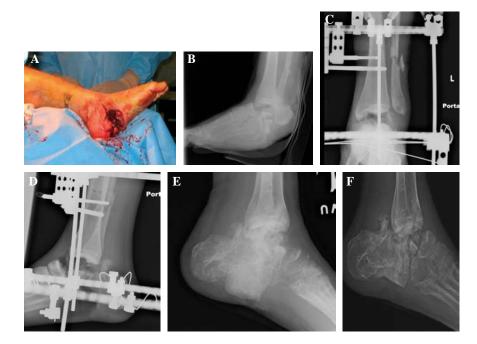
(A) Open comminuted calcaneus fracture, associated with ipsilateral talus fracture with severe bone loss. (B) Lateral radiograph depicting comminuted calcaneus, fibula, and talus fractures with severe bone loss. (C) AP radiograph with spanning ring external fixator maintaining length. Lengthening of the fibula was performed using half-pins and threaded rods. Autograft was harvested from the patient's left femur using the Reamer Irrigator Aspirator System (Synthes). Allograft, reamings, and bone morphogenic protein were utilized in attempted tibiocalcaneal fusion. (D) Lateral radiograph showing maintenance of limb length. (E) Patient went on to a pseudoarthrosis of the attempted tibiocalcaneal fusion. Lateral radiograph demonstrating active plantarflexion and prominent calcaneal exostosis. (F) Lateral radiograph after calcaneal exostectomy.
